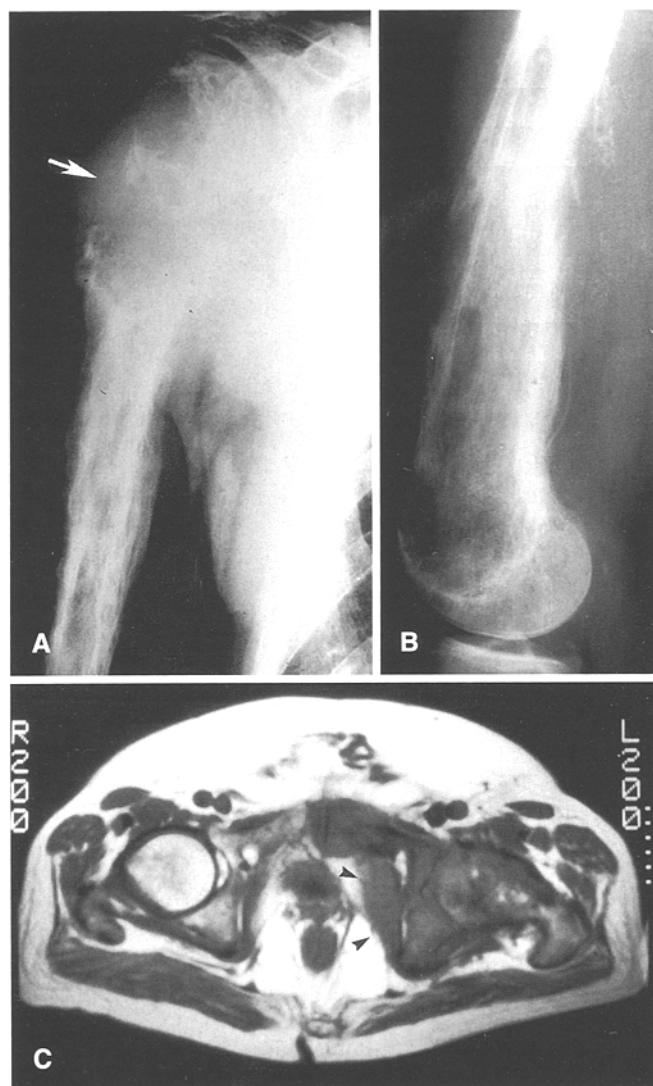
A–C. Paget sarcoma: standard radiography and magnetic resonance findings. A The proximal humerus shows characteristic features of Paget's disease, including bone widening and thickened trabeculae along stress lines in the upper half of the photograph. The signs of malignant transformation are the tumor-like area of destructive lysis in the distal epi-metaphysis and, of even greater significance, a large soft tissue mass (arrow). B This distal femur shows characteristic signs of malignant change, including hazy destruction of the posterior cortex with a definite posterior soft tissue mass and spotty, irregular periosteal reaction. In addition, there is destruction of the anterior cortex by a tumor-like zone of lysis. C Fibrosarcoma of the left proximal femur, acetabulum, and pubis arising in pagetic bone. The axial T1-weighted image shows diffuse loss of marrow fat signal in affected bones with a mass involving the obturator internus muscle (C Reproduced from [11], with permission)
